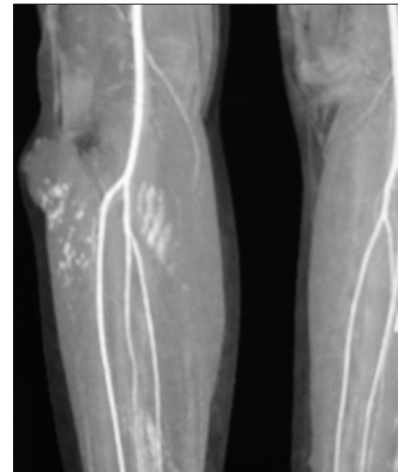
Computed tomography angiogram of lower limb showing feeding vessels
